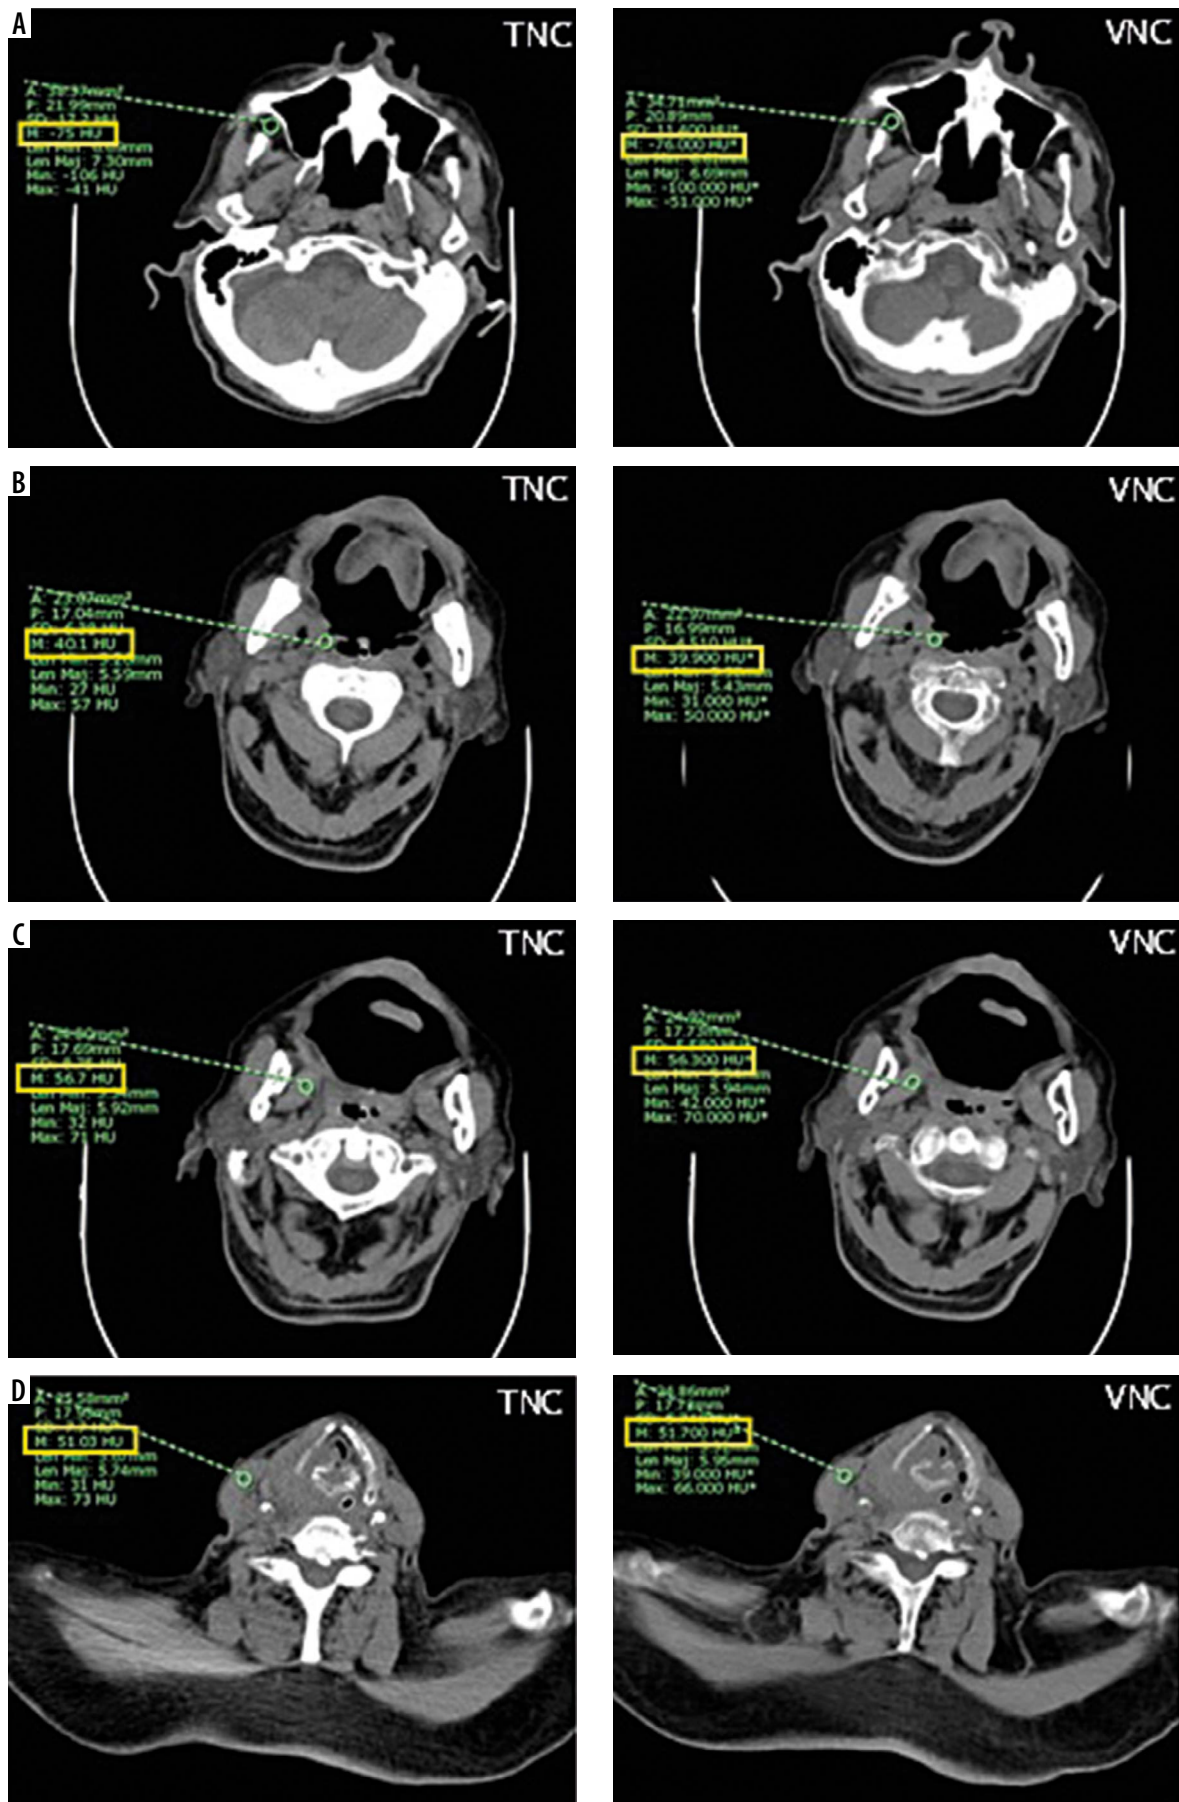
A 84-year-old man with CA supraglottic. Comparison of computed tomography attenuation values of the buccal fat pad (A), tonsillar region (B), medial pterygoid muscle (C), and sternocleidomastoid muscle (D) between axial true non-contrast images (upper row of figure) and axial virtual non-contrast images (lower row of figure) at the same level
